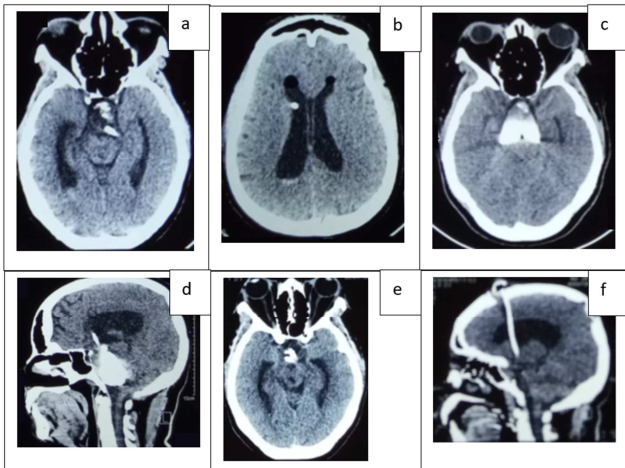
Postoperative CT scan of the first case. Images without injection of contrast on Day 1 of the reservoir implantation: axial section (a); Sagittal reconstruction (b) showing the catheter in the cyst. 4 years after reservoir placement: axial section without contrast (c) showing the catheter in place in a small cyst; Axial contrast cystography (d) and sagittal reconstruction (e) not showing leakage of contrast product. 2 months after intracystic bleomycin: axial section without injection of contrast (f) showing an almost complete drying of the cyst.
